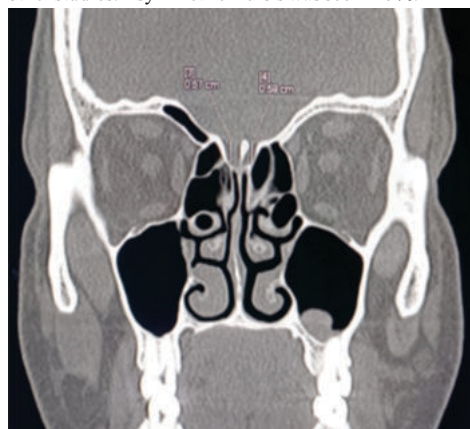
CT coronal image showing Bilateral Keros type II olfactory fossa
